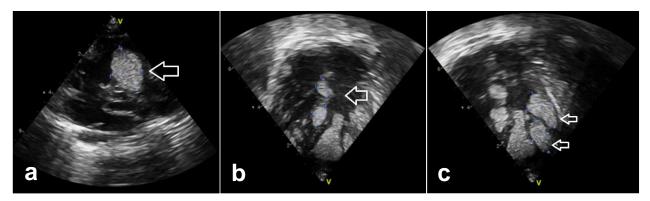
Echocardiography revealed a homogeneous echogenic soft tissue masses (arrows) in the right ventricular outflow tract (a), interventricular septum (b) and left ventricle (c)
